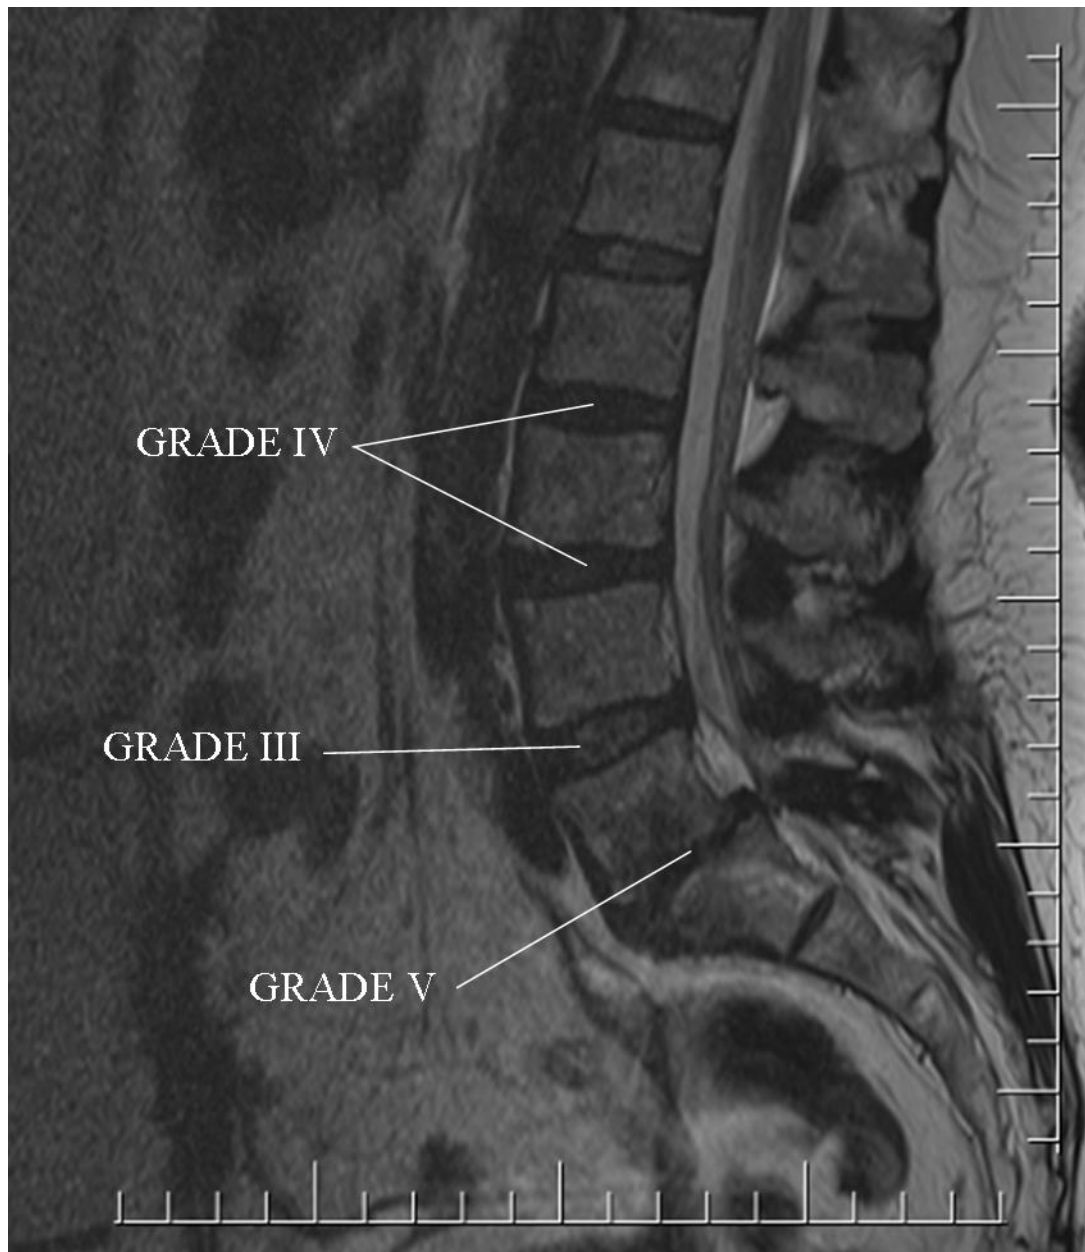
MRI of lumbar spine showing Pfirrmann's disc degeneration grade III (inhomogeneous disc with intermediate grey signal intensity), grade IV (inhomogeneous disc with hypointense dark grey signal intensity) and grade V (inhomogeneous disc with hypointense black signal intensity and collapsed disc space). Magnification: 0.65 X
